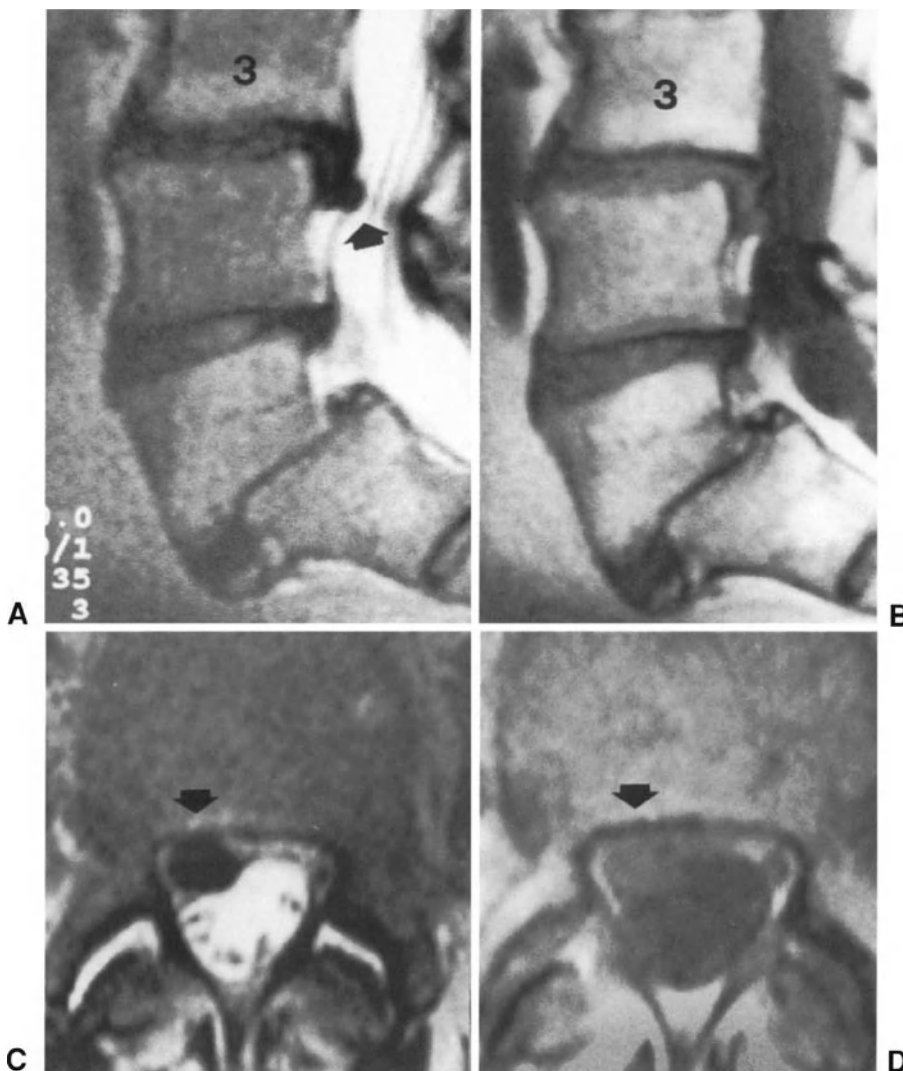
A patient with retrolisthesis of L3 and disc herniation at L3-L4 level. (A) and (B) Spin-echo T2-weighted and T1-weighted sagittal MR scans, respectively, showing marked retrolisthesis of L3 and extruded herniation at the level below (arrow). Mild retrolisthesis of L4 and isthmic spondylolisthesis of L5 are also present. (C) and (D) Turbo spin-echo T2-weighted and T1-weighted axial MR scans, respectively, revealing extruded disc tissue in the right nerve-root canal of L3 (arrows). The patient underwent laminotomy and discectomy with complete resolution of the symptoms.
